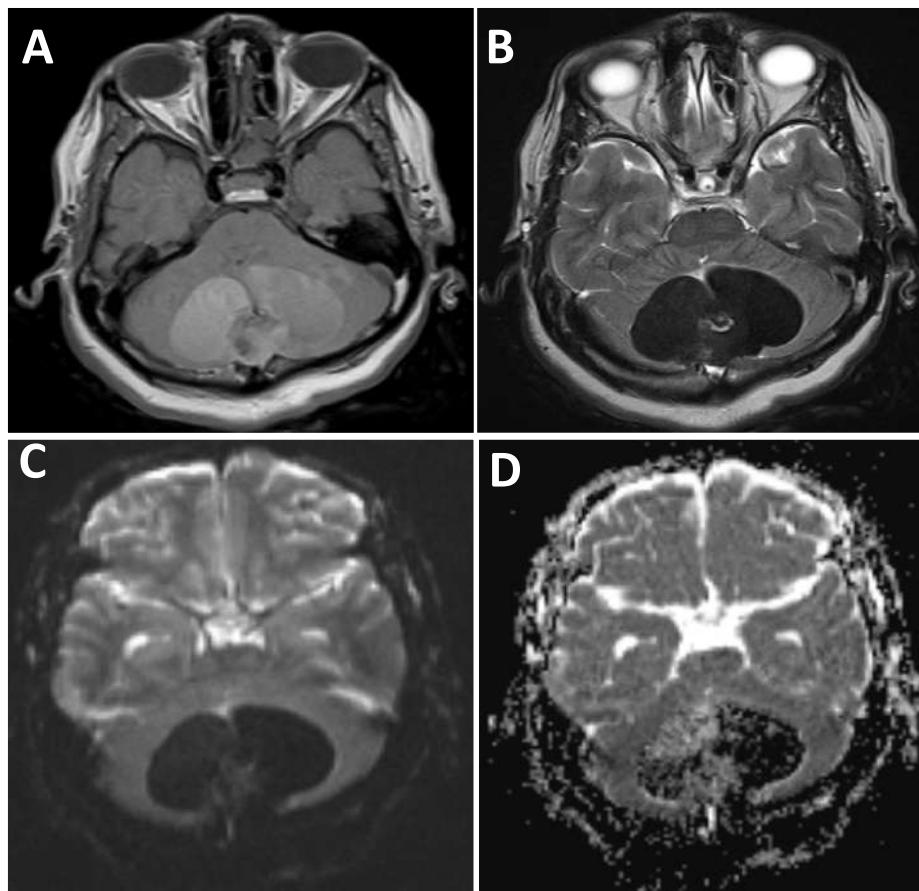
axial brain MRI showing a well-circumscribed lesion at the midline posterior fossa, which is profusely hypointense on T2-weighted sequences and hyperintense on T1-weighted sequences with a small midline transdiploic channel (A, B). DWI and ADC show no diffusion restriction of the lesion (C, D).
